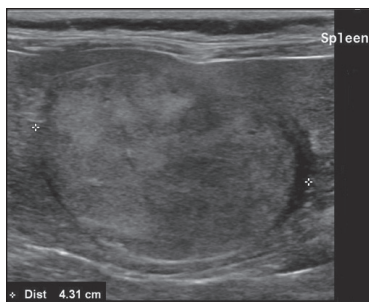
Ultrasound image shows a large heterogeneous mass in the spleen. The mass measured 2.9×4.3 cm.
